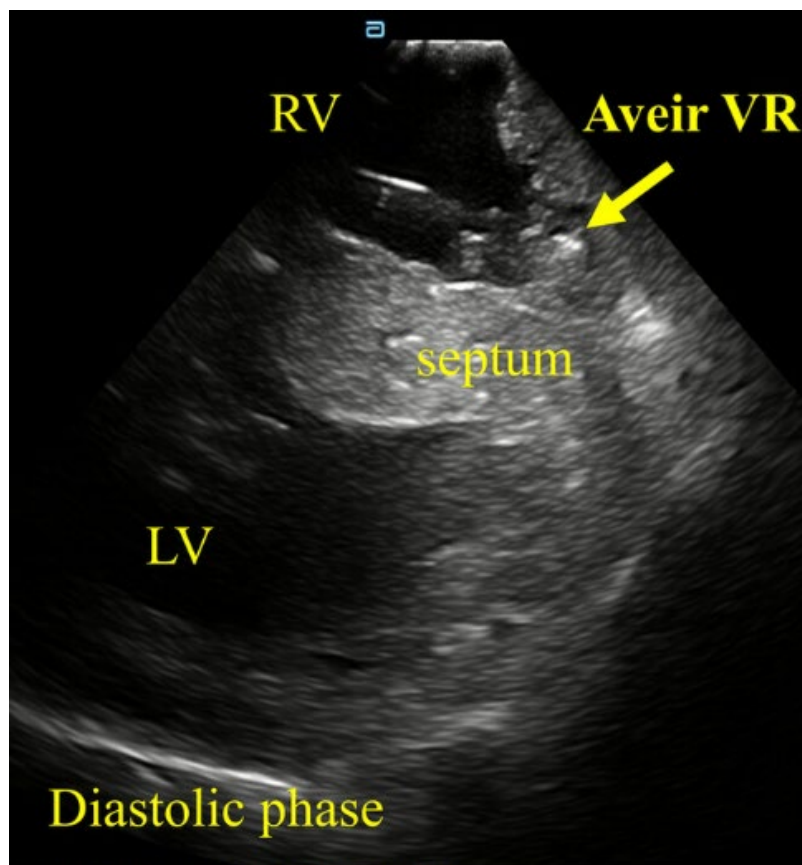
Matsumoto K et al. demonstrated the safety of intracardiac echocardiography (ICE)-guided leadless pacemaker implantation in patients with contraindications to contrast agents, such as contrast media allergy.¹⁹
